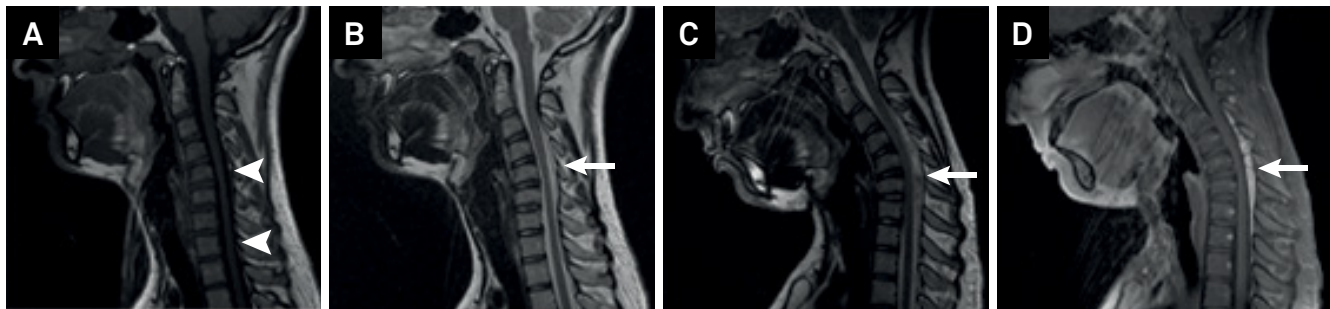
Neutral cervical spine MRI sagittal images (A and B). In A, a T1-weighted image shows C6-T1 cord atrophy (arrowheads) and in B a T2-weighted image demonstrates slight detachment of the posterior dura mater (arrow). Flexion cervical spine MRI sagittal images (C and D). In C, a T2-weighted image reveals forward displacement of the posterior wall of the dural sac with some impression over the cord (arrow). In D, a contrast-enhanced T1-weighted image shows engorgement of the posterior epidural venous plexus, with enhancement (arrow).
